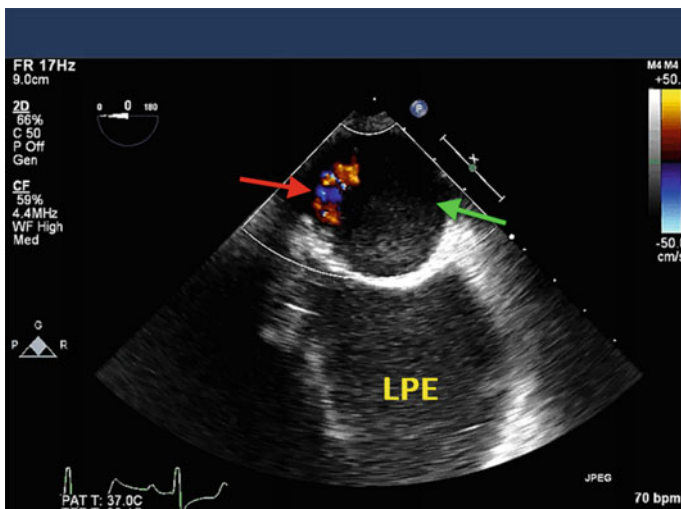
Descending thoracic aortic short axis view with color flow Doppler in a patient with an aortic dissection and a large left pleural effusion (LPE). The *red arrow* indicates the true lumen; the *green arrow* notes the false lumen
